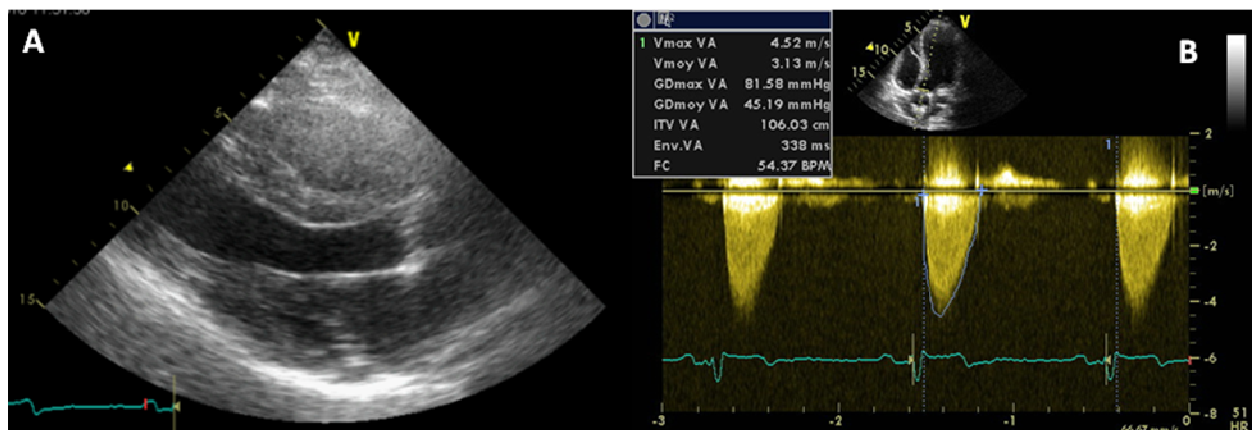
Case n°3 (A) preoperative bidimensional echocardiography; (E) preoperative Doppler echocardiography.
